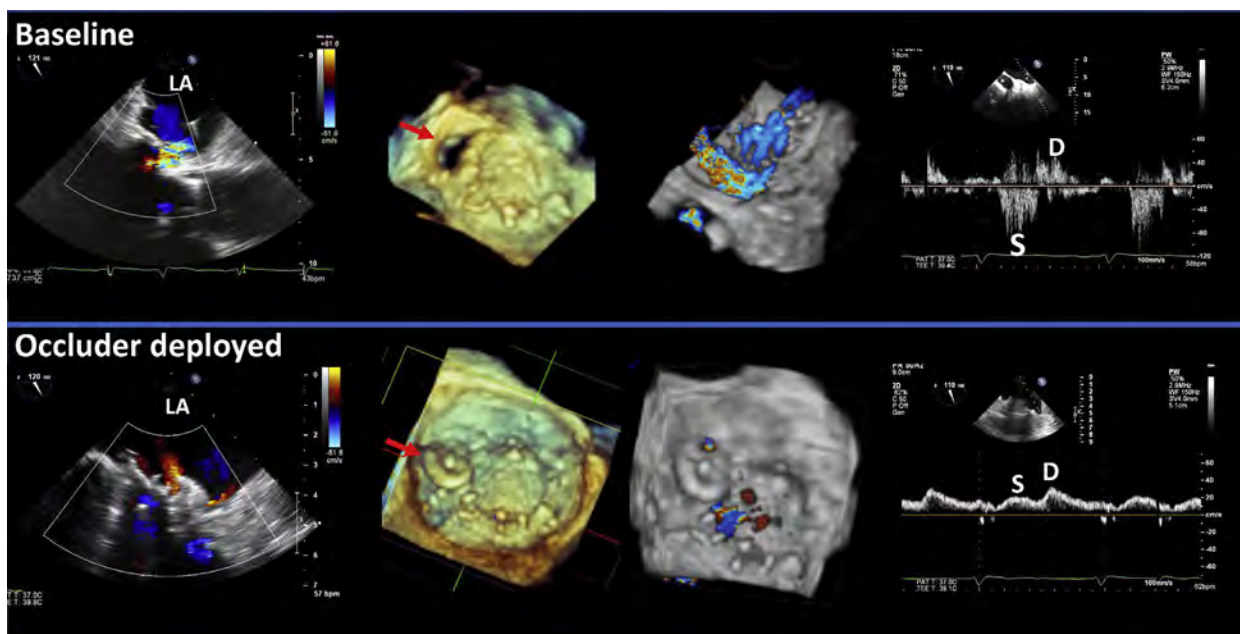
Plug repair for mechanical MV paravalvular regurgitation. At baseline: 2D color Doppler depicts paravalvular MR with a vena contracta diameter of 7 mm. A large paravalvular defect is noted at the 10 o'clock location (*arrow*). 3D color Doppler depicts a large paravalvular MR jet. The left upper pulmonary vein demonstrates systolic flow reversal (S). After deployment of an occluder: 2D color Doppler depicts two very small MR jets on either side of the repair device. The device is appropriately deployed within the paravalvular defect (*arrow*). 3D color Doppler depicts a very small residual paravalvular MR jet at the superior margin of the occluder device. Left upper pulmonary vein flow demonstrates systolic blunting but no reversal of flow.
